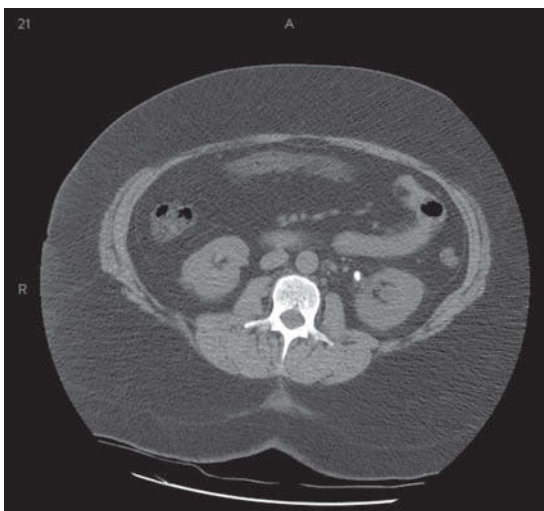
Kidney stone. Axial CT scan demonstrating a calcific opacity adjacent to the left kidney, consistent with a calculus in the proximal ureter. Courtesy: Gus M. Garmel, MD.
